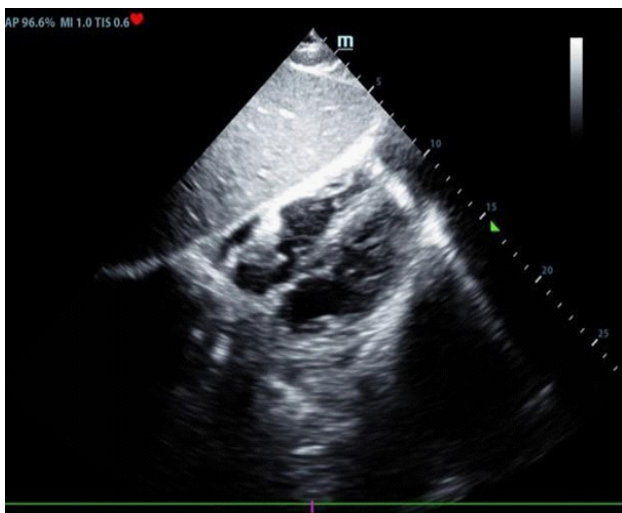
Transthoracic Doppler echocardiogram, subxiphoid window, demonstrating a vegetation on the right atrial free wall.
